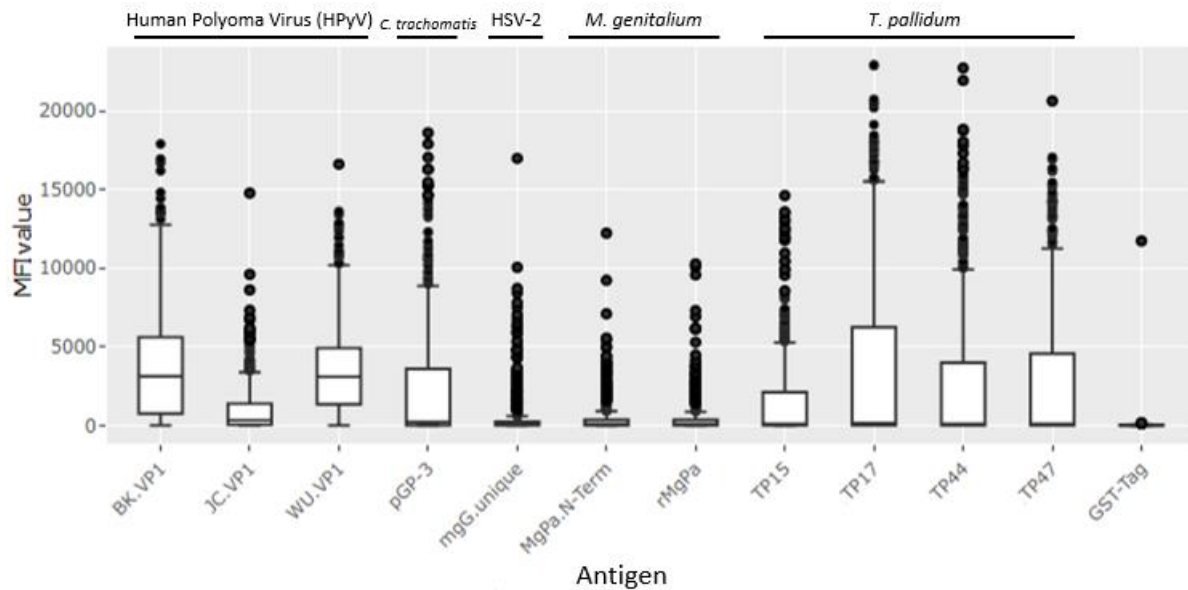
Median fluorescent values (MFI) by Luminex analyzer for IgG/IgM/IgA in sample sera for *T. pallidum* antigens. Most values measured < 5000 MFI, with a heavy skew towards zero. Host pathogen of the respective antigen is indicated at the top. CT = *C. trachomatis*.
